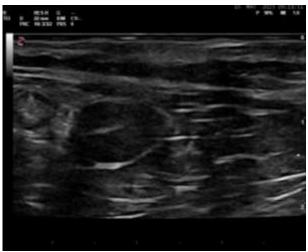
Tomcat, 3 years. Sagital ultrasound of the right caudal quarter of the abdomen showing the right testicle located caudally of the intestines.
